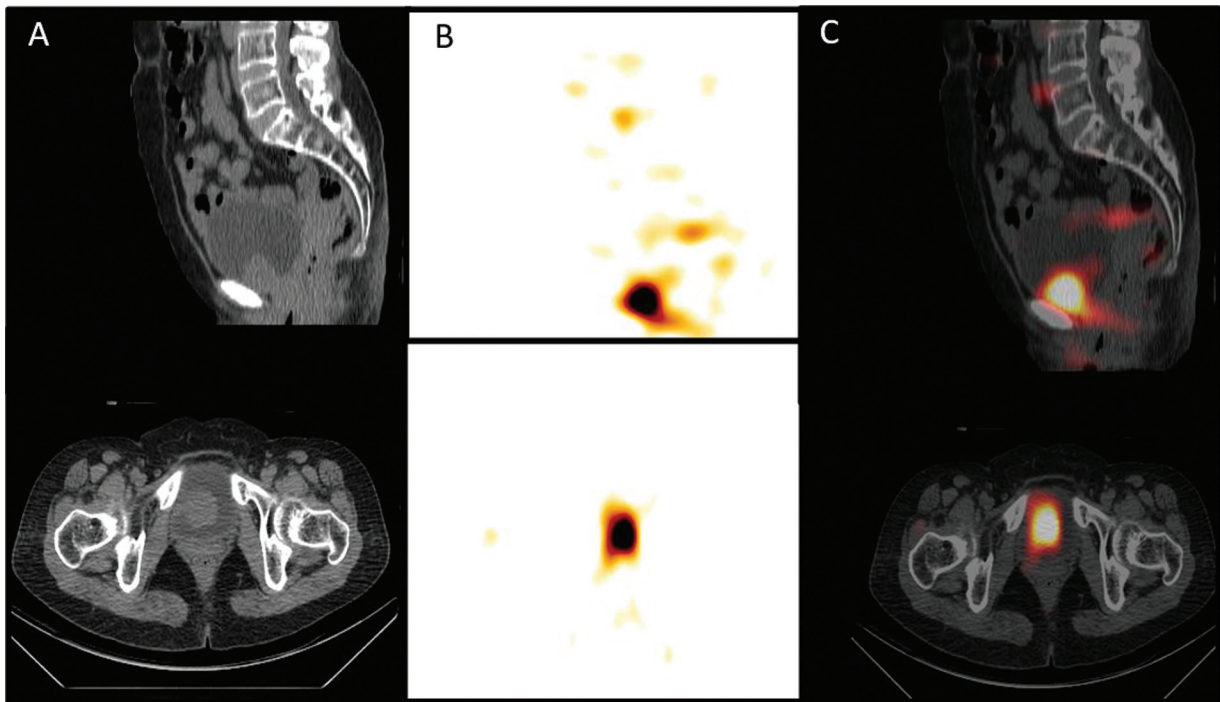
Iodine-131 meta-iodobenzylguanidine single-photon emission computed tomography (^{131}I MIBG SPECT/CT) images of pelvis showing MIBG avid discrete, soft tissue density intraluminal exophytic mass lesion arising from right lateral wall, near the neck of urinary bladder and extending into bladder lumen, measuring 4.1×3.4 cm in size. Marked clearance of background tracer activity seen in the urinary bladder at 48 hours. (A) Sagittal and axial section CT images, (B) functional images, and (C) fused SPECT/CT images.
